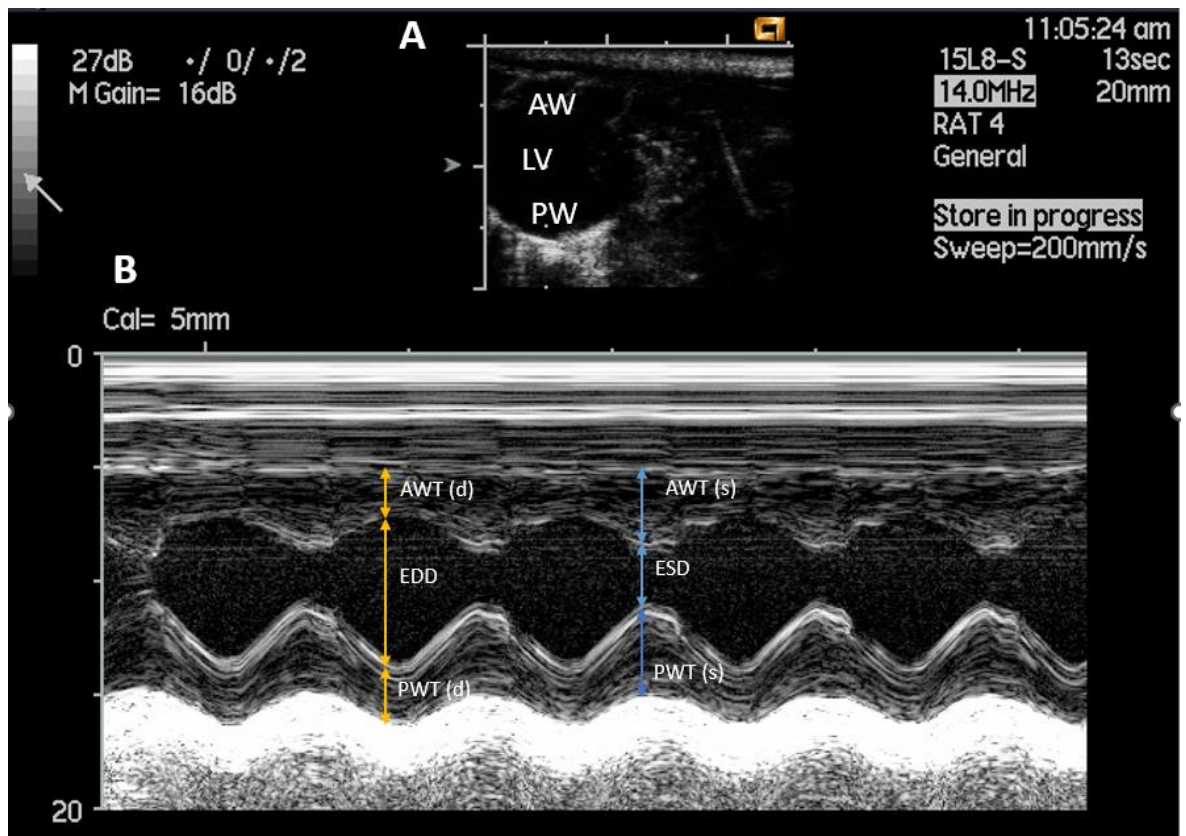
A representative of echocardiography image
